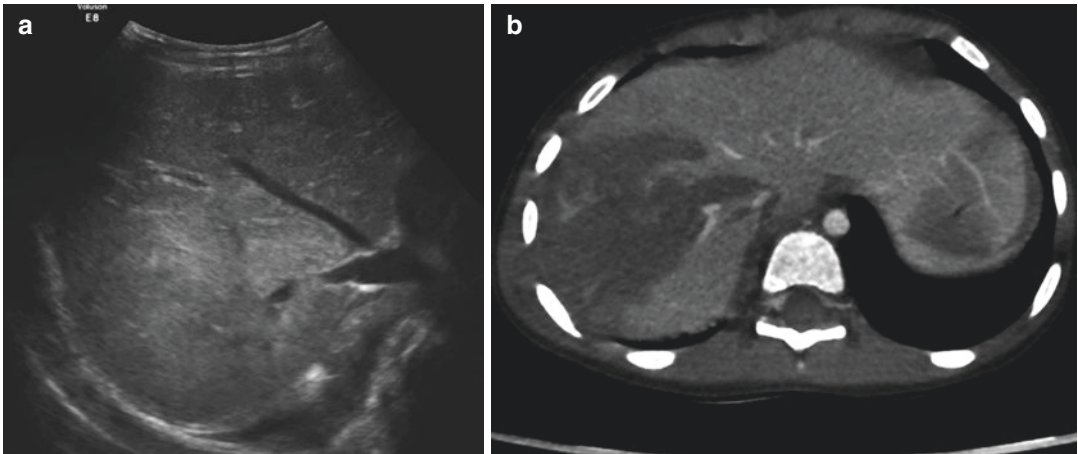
Five year old girl. Auto crash. (a) US transverse scan: Initial US only shows heterogeneous right liver lobe. (b) CT with contrast: CE-CT shows grade IV liver lesion
